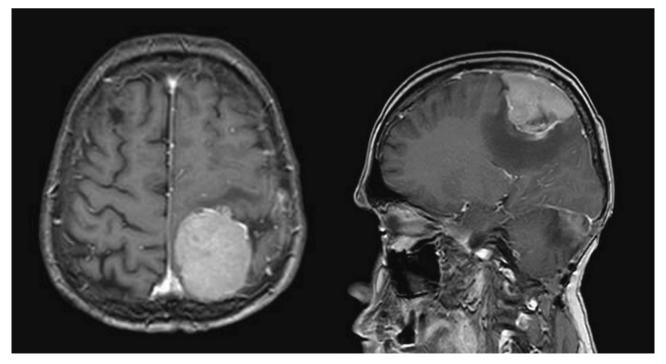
A well-defined enhancing oval mass in the left parietal lobe measuring about 6 × 4 × 2 cm in T1-weighted MRI with Gadolinium contrast.
